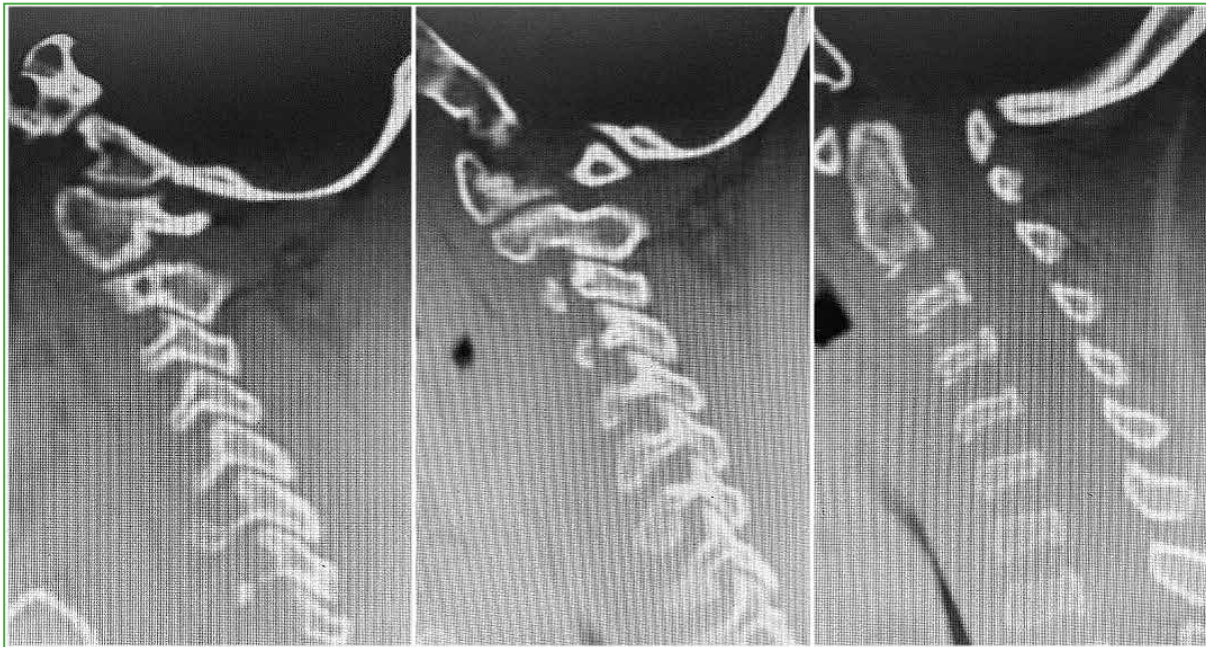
Cervical computed tomography, sagittal section. A decrease in the height of the C3-4-5 vertebral bodies is visualized, with no other bone anomalies.
